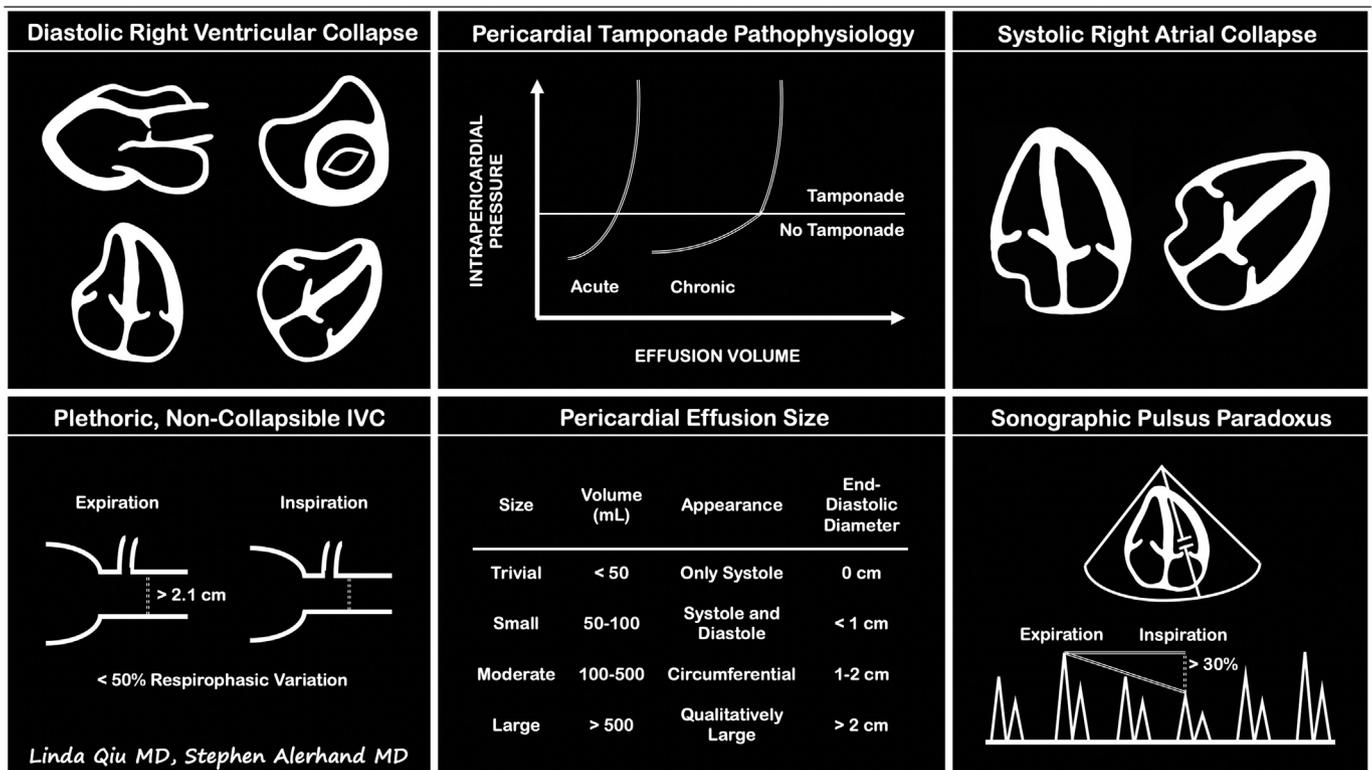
Infographic delineating the pathophysiology and echocardiographic findings of pericardial tamponade (echocardiography graphic design by Linda Qiu MD).
